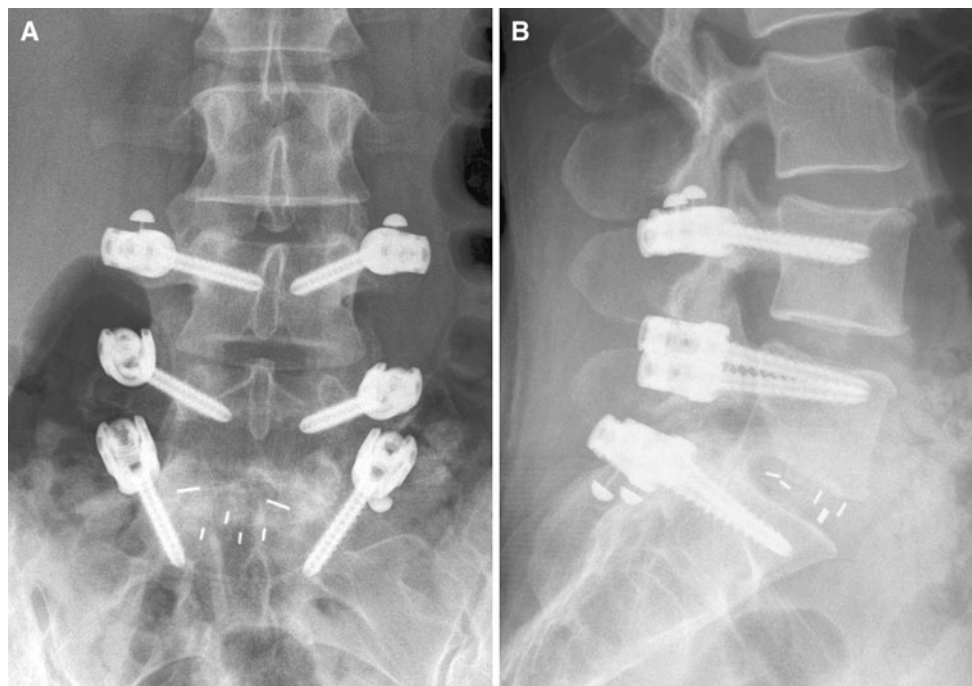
Pre-revision antero-posterior and lateral radiographs of a female patient, implanted with PEEK rods as a hybrid stabilization of L4–S1 (Case 10, Table 1), in which the original intent to treat the patient was nonfusion L4–L5 and fusion L5–S1. Revision took place
